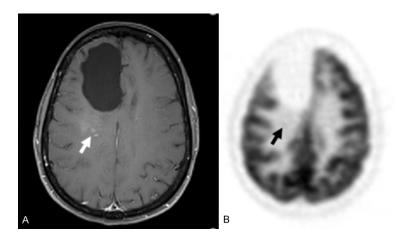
37-year-old female with recurrent right frontal anaplastic astrocytoma treated with resection followed by radiation therapy with concurrent temozolomide and Carmustine. Follow-up Gd-MRI (A) showed small areas of nodular enhancement posterior to the resection cavity concerning for tumor recurrence (white arrow). FDG-PET scan (B) showed only subtle uptake posterior to the resection cavity corresponding to the foci of nodular enhancement on MRI (black arrow). (SUVmax = 3.1, ratio of SUVmax/WM = 0.95). The survival in this individual was 14 months from the time of FDG-PET.
